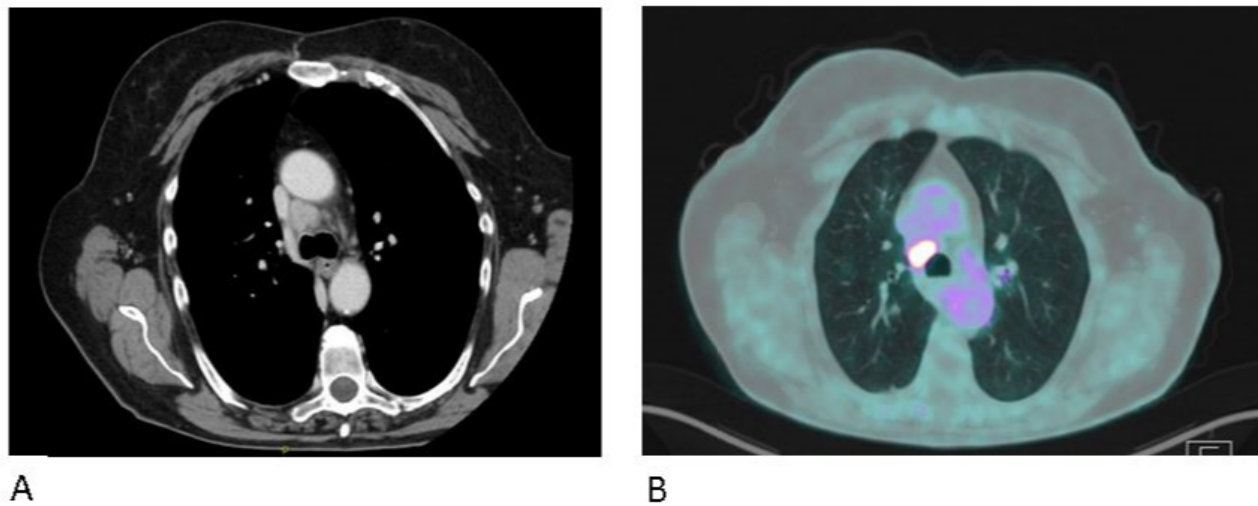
Preoperative work out. A. CT scan showing lymph nodes with short axis larger than 1 cm in the right lower paratracheal station. B. PET/TC revealing ¹⁸FDG avid lymph nodes in the right lower paratracheal station.
